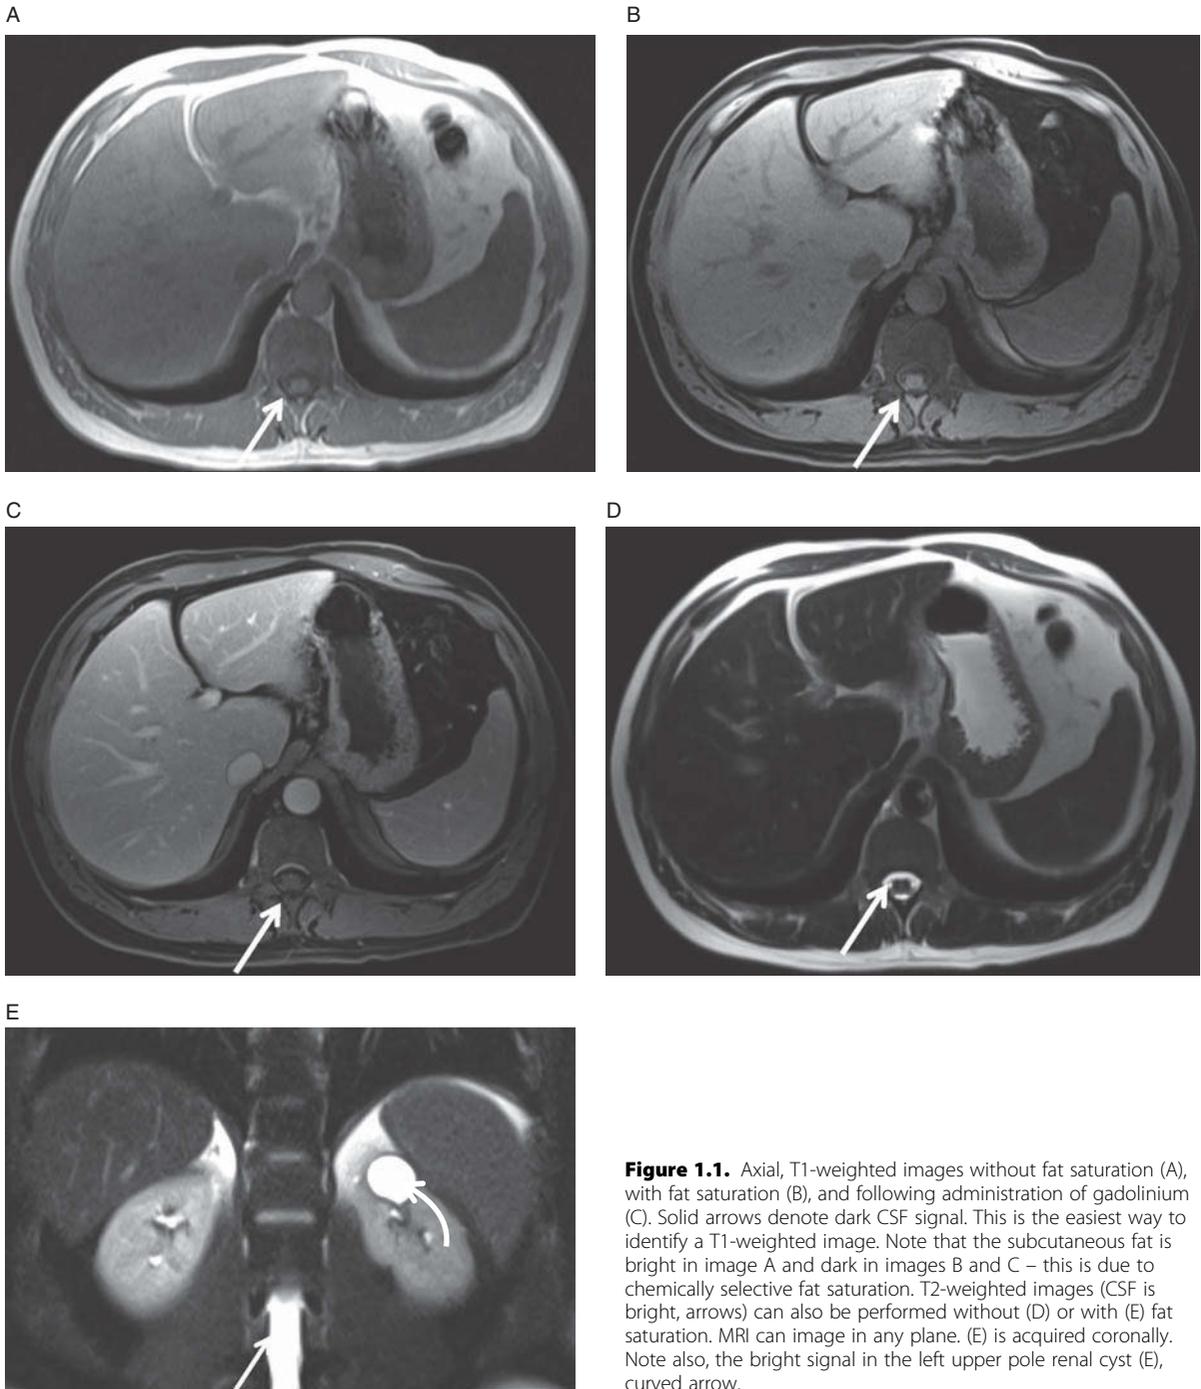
Axial, T1-weighted images without fat saturation (A), with fat saturation (B), and following administration of gadolinium (C). Solid arrows denote dark CSF signal. This is the easiest way to identify a T1-weighted image. Note that the subcutaneous fat is bright in image A and dark in images B and C – this is due to chemically selective fat saturation. T2-weighted images (CSF is bright, arrows) can also be performed without (D) or with (E) fat saturation. MRI can image in any plane. (E) is acquired coronally. Note also, the bright signal in the left upper pole renal cyst (E), curved arrow.
